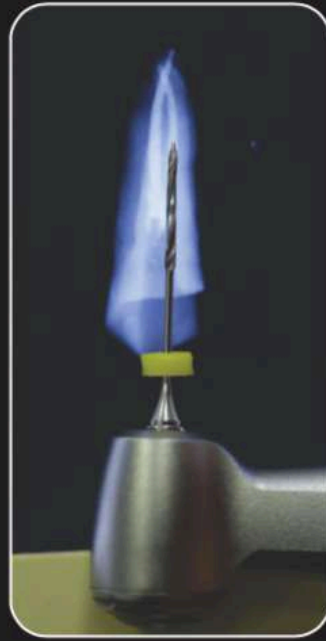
The post length is tentatively determined on an IOPA radiograph using a peeso reamer. The tip of the buccal cusp (in this case) is chosen as the anatomic landmark from which measurements are made. The palatal canal is chosen as the primary canal and prepared up to the predetermined length using the # 1 peeso reamer in a slow speed contra-angle handpiece.
